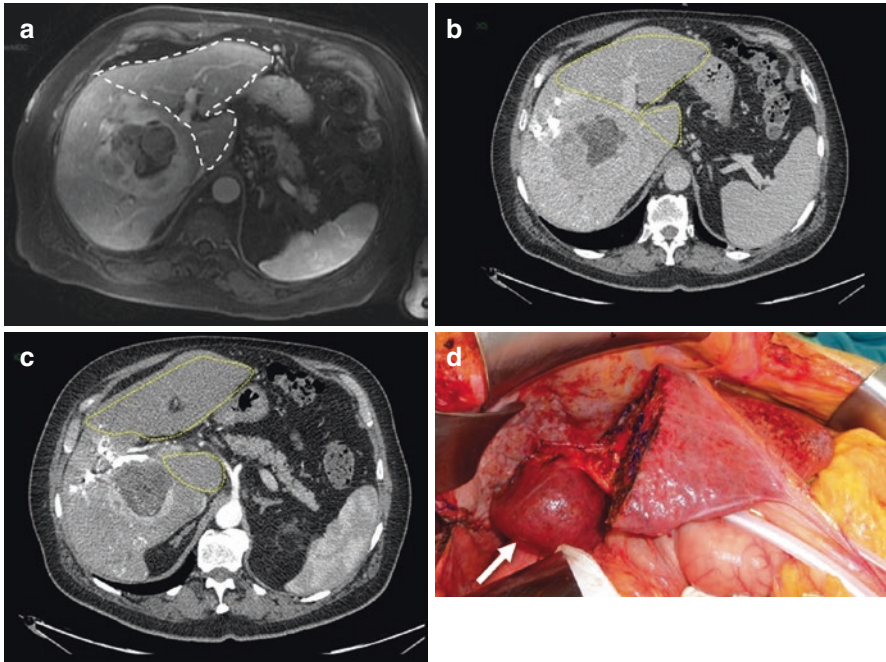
Sixty-six-year-old male. (a) CT scan: large hepatocellular carcinoma on non-alcoholic fatty liver disease-related cirrhosis. Indication for right hepatectomy; small functional remnant liver volume (FRLV) (32%). (b, c) CT scan after right portal vein embolization: FRLV 43%. (d) Right hepatectomy. Note the caudate lobe hypertrophy (white arrow)
